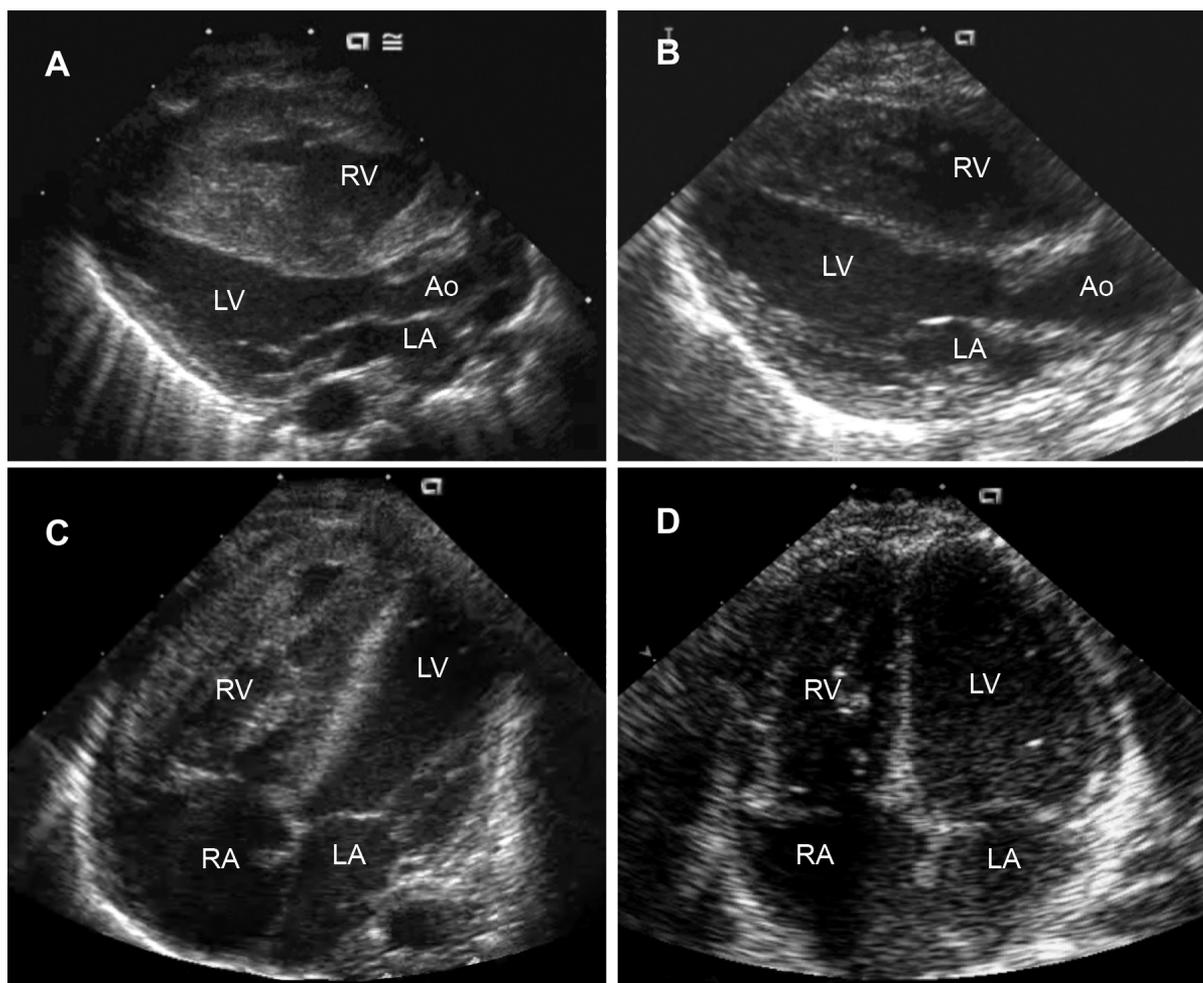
Transthoracic echocardiogram. Parasternal long axis view (A) and apical 4-chamber view (C), demonstrating striking right ventricular hypertrophy (RVH). Parasternal long axis view (B) and apical 4-chamber view (D) 14 weeks later, demonstrating resolution of RVH.
